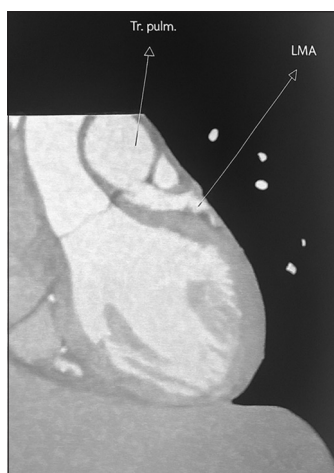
Computed tomography of the heart: Truncus pulmonalis with left main coronary artery (LMA): The LMA starts from the cranial contour of the truncus pulmonalis, that is, it is anomalous origin of the left coronary artery from the pulmonary artery.
